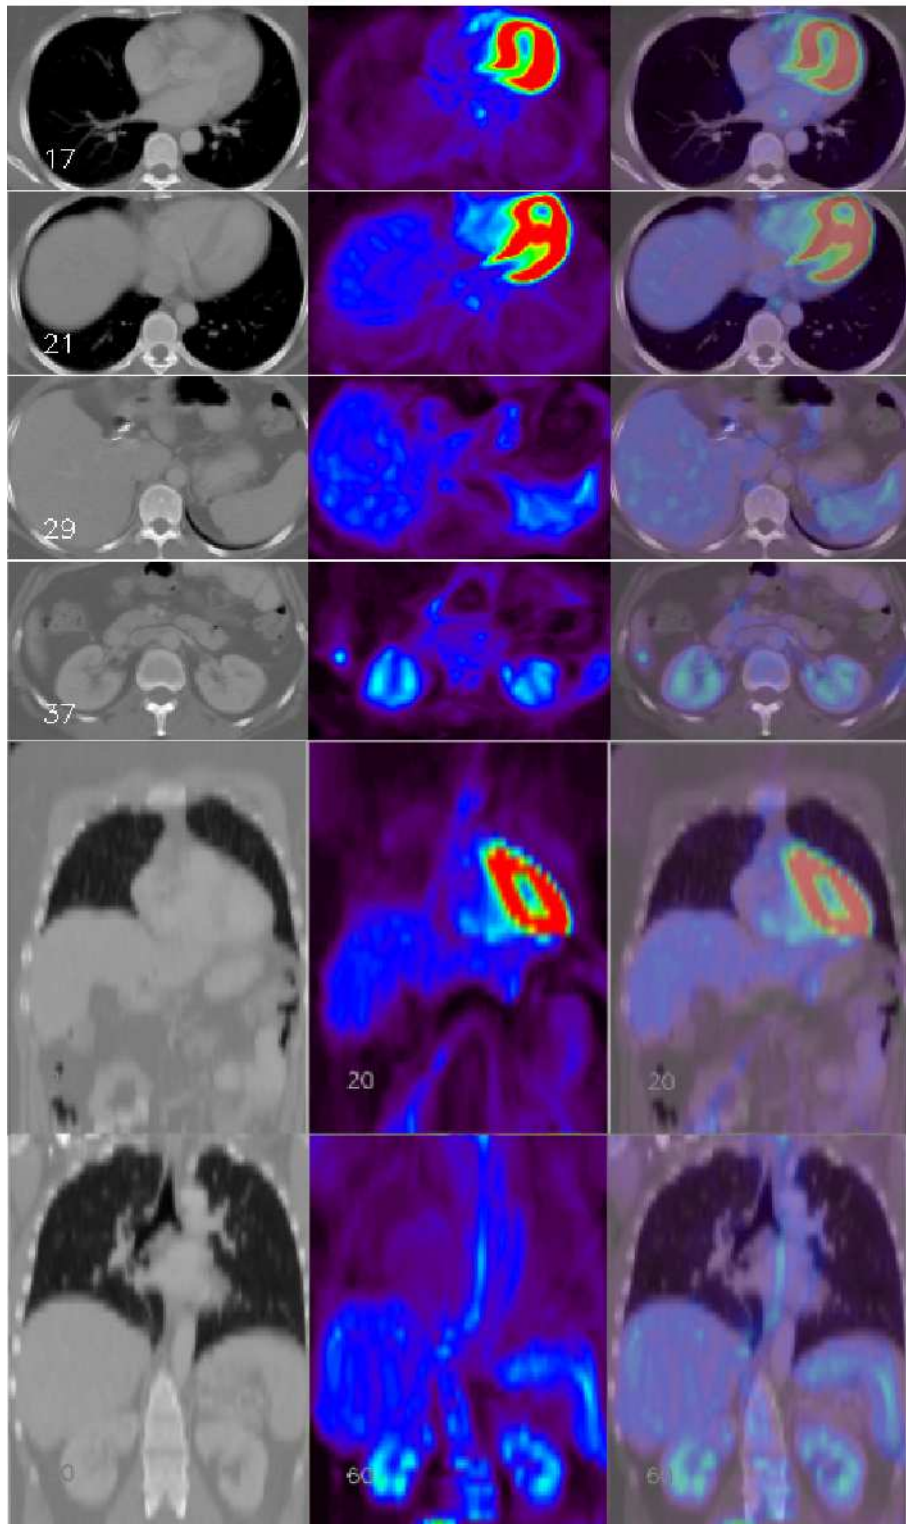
Final registration result. Case 1. Axial (four top rows) and coronal (two bottom rows) 2D slices of the CT (left) and registered (with the proposed registration methodology) emission PET (center) images and their superimposition (right).
